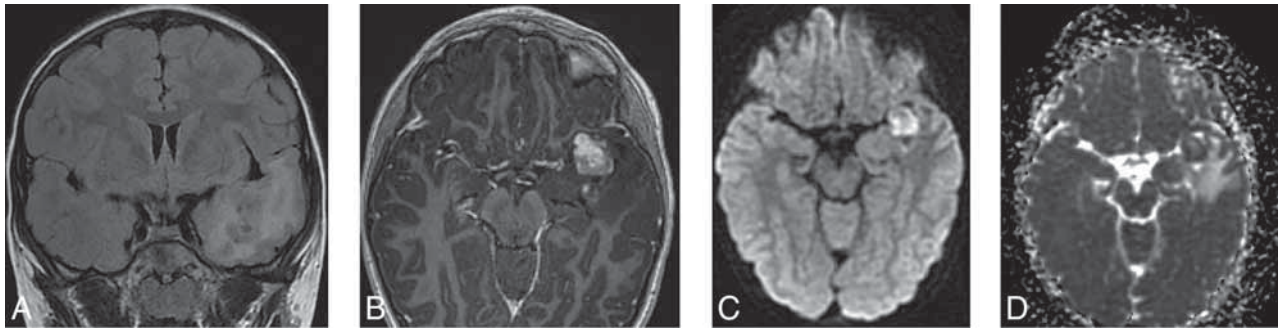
A 9-year-old boy with seizures. The brain MR imaging shows an ill-defined mass lesion with tiny internal cystic changes on T2 FLAIR (A) involving the mesial aspect of the left temporal lobe. The lesion shows moderate surrounding edema, mild mass effect against surrounding structures, as well as moderate enhancement (B). On DWI (C) and ADC (D), the mass shows diffusion restriction. The final tissue diagnosis was ganglioglioma with a *BRAF* V600E mutation.
